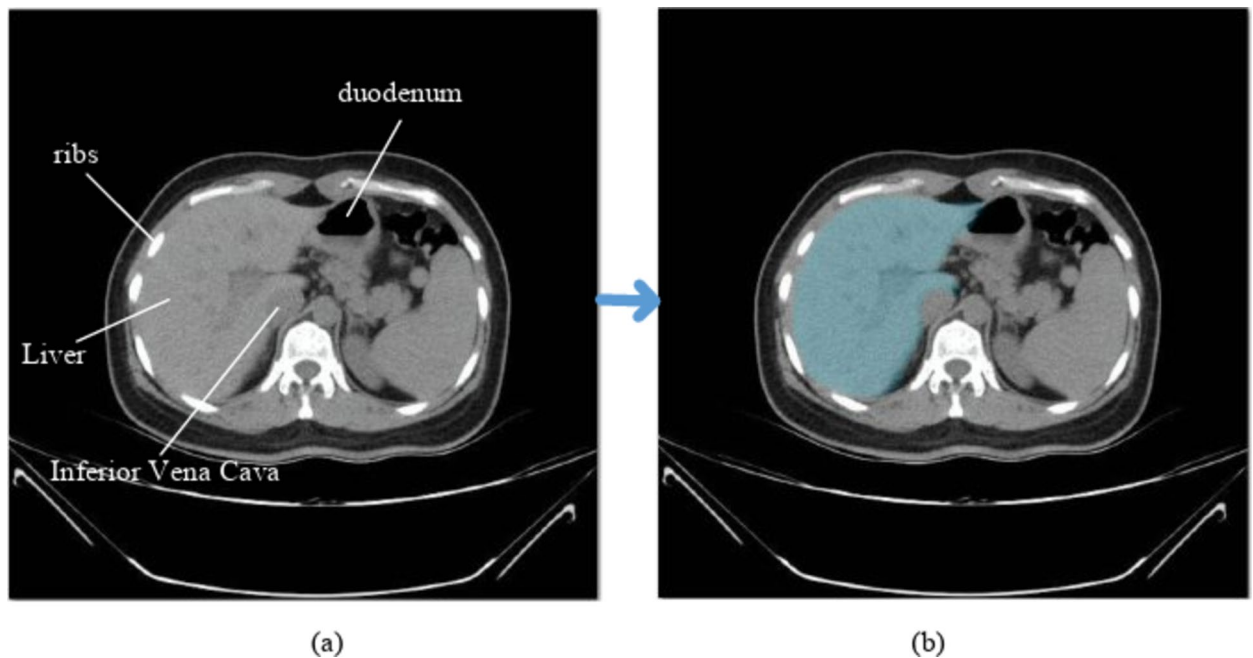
(a) Original CT image with annotated anatomical structures (liver, ribs, duodenum, and inferior vena cava). (b) Segmented liver region (blue) demonstrating accurate boundary delineation by the proposed model.
